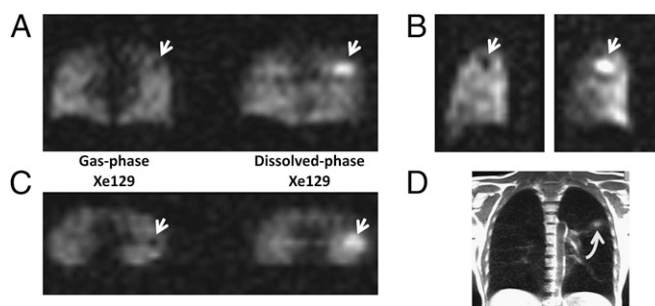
Dissolved-phase Xe129 accumulated in the pulmonary nodule that was incidentally found in subject 3 (healthy). (A–C) Coronal (A), sagittal (B), and axial (C) reconstructions from a 3D acquisition highlighting the correspondence between the focal region of elevated dissolved-phase signal intensity in the upper left lung and a ventilation defect (arrows). (D) Coronal proton MRI image showing a 1-cm pulmonary nodule (curved arrow) at the same location. MRI pulse-sequence parameters for the 3D acquisition included TR, 35 ms; TE, 2.8 ms; flip angle at dissolved phase, 16°; bandwidth, 110 Hz/pixel (6.2 ppm/pixel); and spatial resolution, 12 × 12 × 12 mm.
